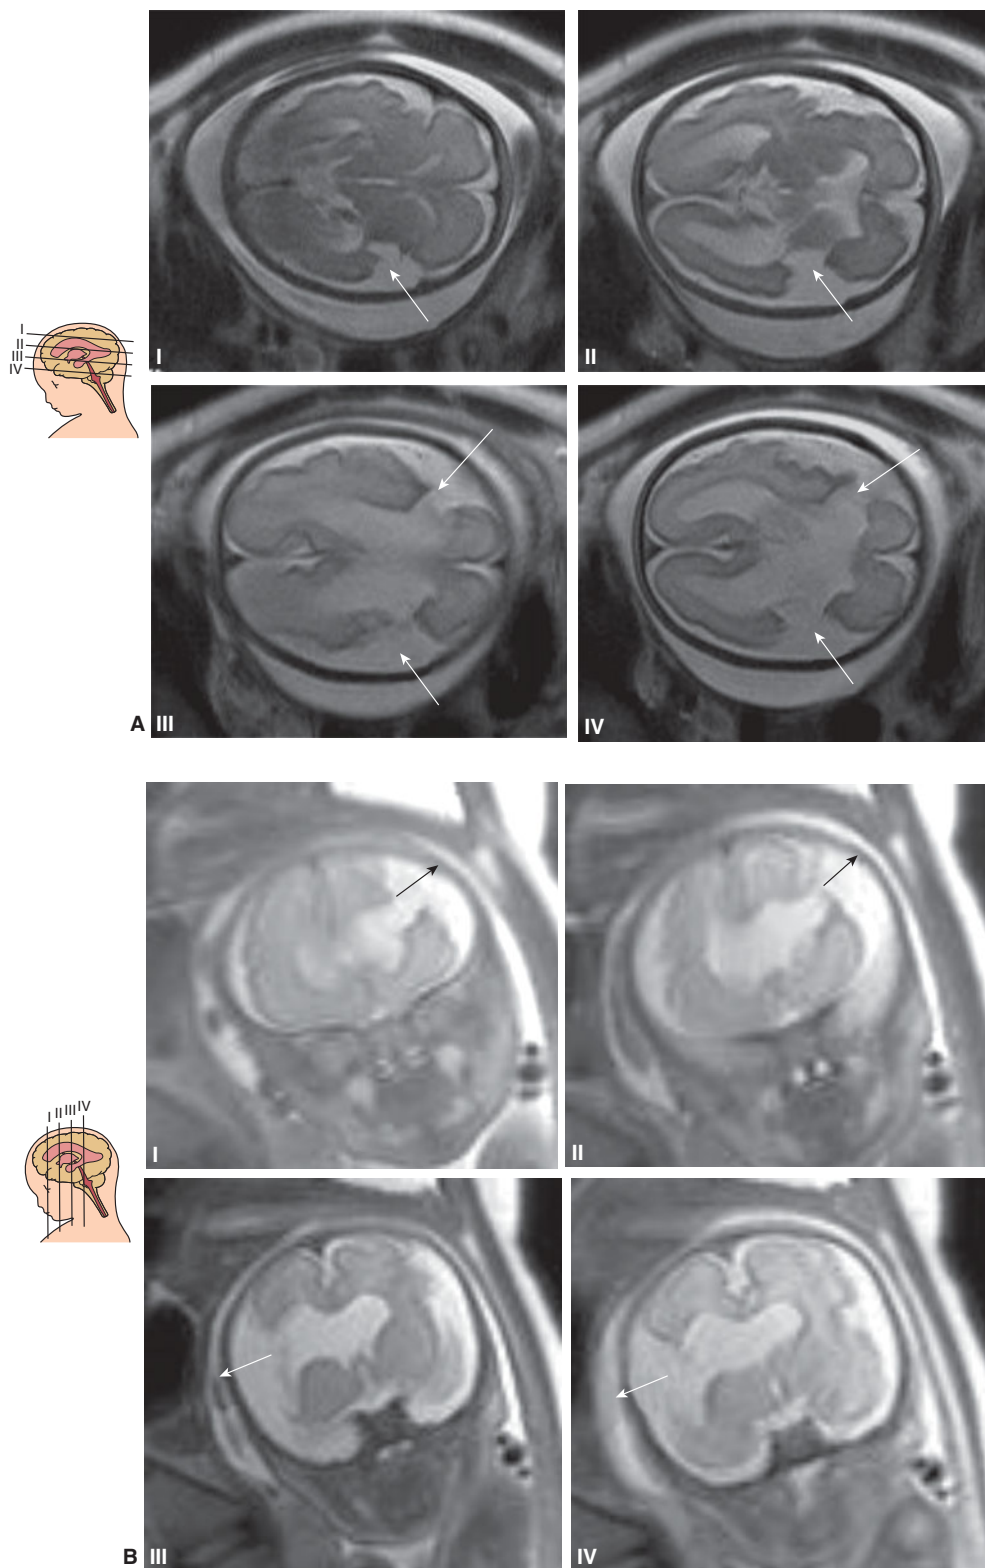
Serial magnetic resonance imaging (MRI) of bilateral open-lip schizencephaly. The arrows point to the clefts. (A) Axial plane. (B) Coronal plane.
